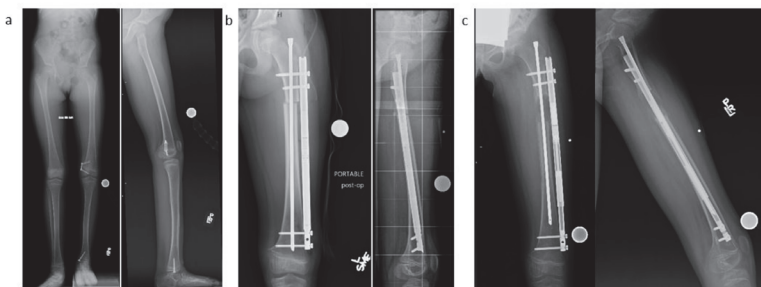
(a) AP and lateral long leg radiographs of eight year old with congenital femoral deficiency and 4.5 cm leg length discrepancy. Goal lengthening was 4 cm. (b). Immediate postoperative AP and lateral radiographs demonstrate internal extramedullary femoral lengthening with 10.7 x 275 mm retrograde straight PRECICE nail and two 5.0 mm screws proximally and two 4.0 mm screws distally. 4.8 mm SLIM nail was utilized for intramedullary stabilization. (c) AP and lateral follow up radiographs two months after surgery demonstrate 4.2 cm of lengthening.
